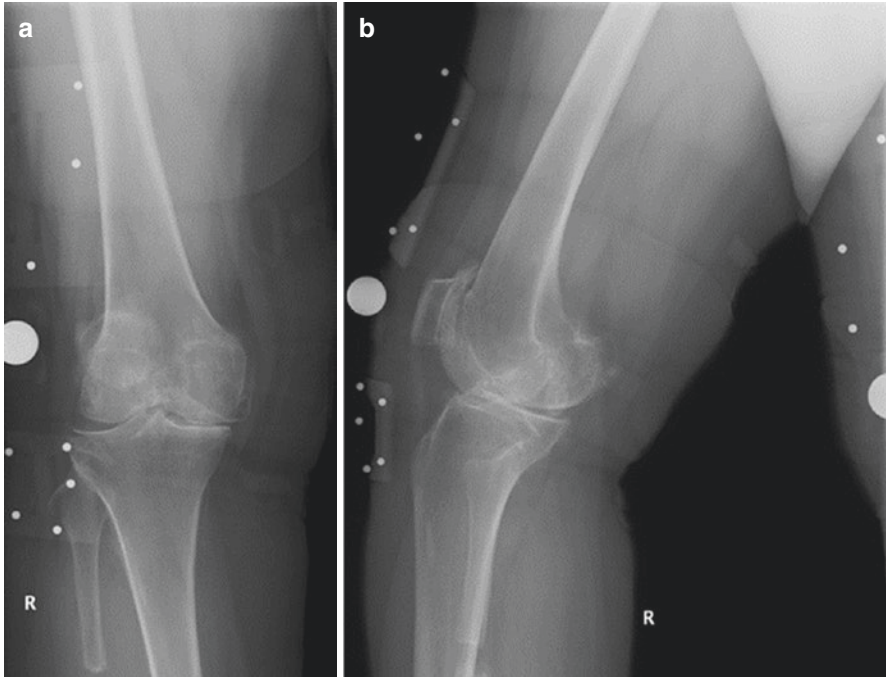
Immediately postoperative radiographs; anteroposterior (a) and lateral (b)
